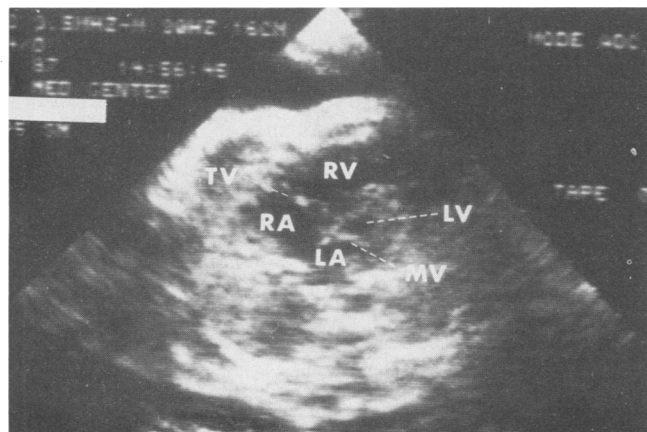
A fetal echocardiogram with a 4-chamber view of the heart at a gestational age of 35 weeks shows a hypoplastic left ventricle (LV) with mitral atresia and an enlarged right ventricle (RV). LA = left atrium, MV = mitral valve, RA = right atrium, TV = tricuspid valve
